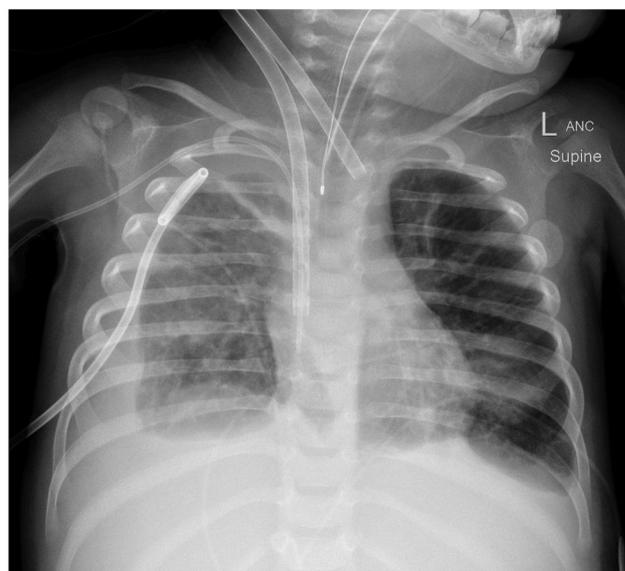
VA ECMO cannula position Appropriate placement of VA ECMO cannula on chest Xray.
